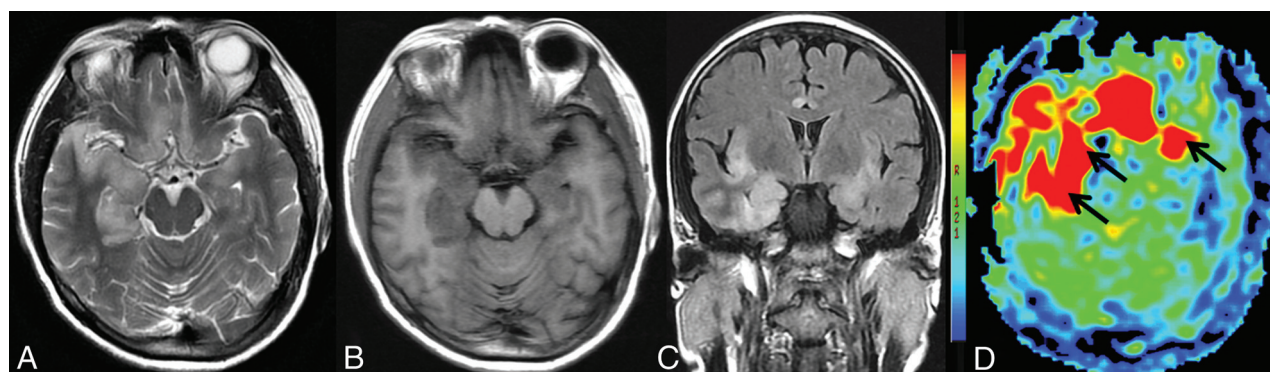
Case 12, a 47-year-old female patient at the subacute stage (15 days after the onset of symptoms). A, Axial T2WI shows hyperintensities in bilateral frontal, temporal, and insular lobes and the cingulate gyrus. B, Axial TIWI demonstrates slight hypointensities. C, Slight hyperintensities are observed on coronal T2 FLAIR. D, 3D-pCASL shows high perfusion (black arrows) in the corresponding involved areas.
